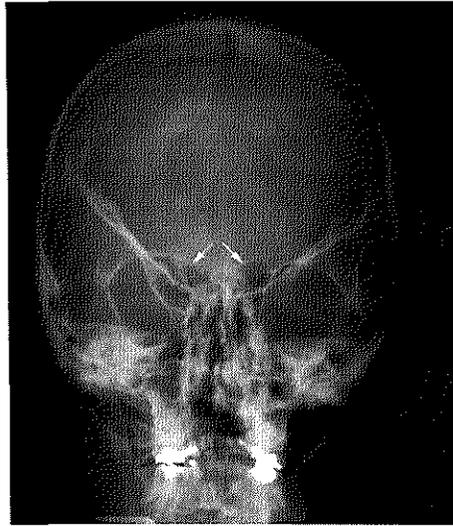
Skull X-ray of member II:2 of family 2 at age 34 showing hypoplasia of the frontal sinus.
